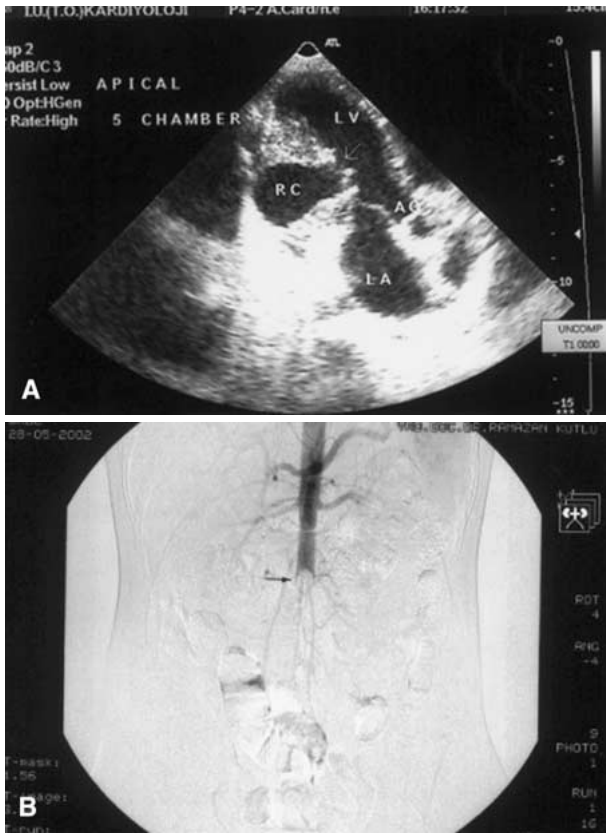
A Transthoracic echocardiographic view showing the residual cyst cavity (RC) of hydatid cyst at the post-erolateral wall of the left ventricle. The *white arrow* shows the rupture orifice. LA, left atrial cavity; LV, left ventricular cavity; AO, aortic valve. B Digital subtraction angiogram showing total occlusion of abdominal aorta just above the iliac bifurcation. The *black arrow* shows the cyst.
